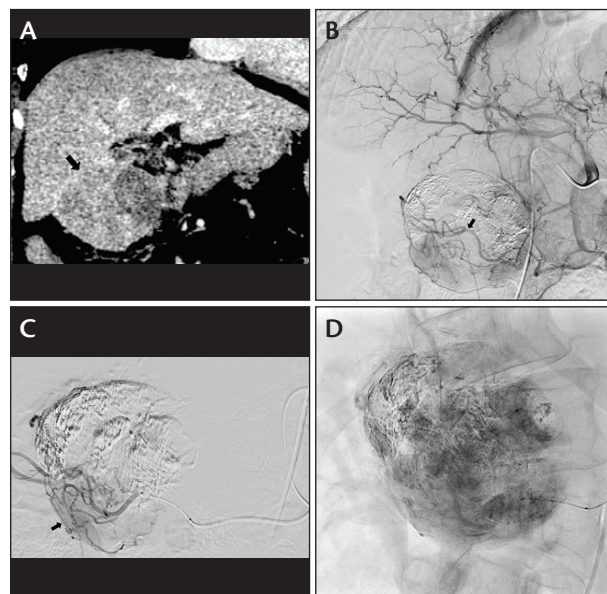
Contrast-enhanced CT coronal reformation after TACE for exophytic right liver lobe HCC (A). Gastroduodenal artery (B) and omental branch (C) angiograms confirmed omental artery supply to the viable portion of the tumor. A fluoroscopic spot image demonstrated accumulation of ethiodized oil within the embolized portion of the mass after TACE (D).
